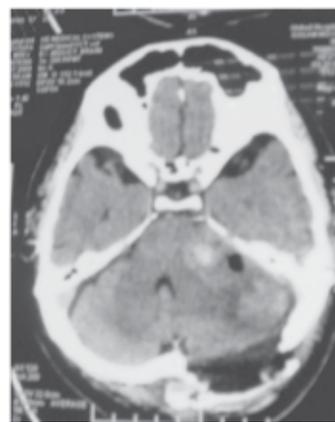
Axial CT post-contrast
